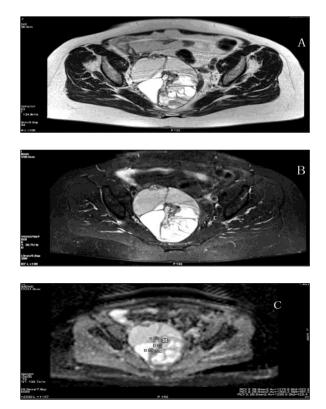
(A): A large primary ovarian multicystic tumor on T2-weighted; (B): on T2 STIR; (C): Diffusion-ADC maps. Small ROI is placed on a region appearing to be the most enhancing solid part of the tumor.
